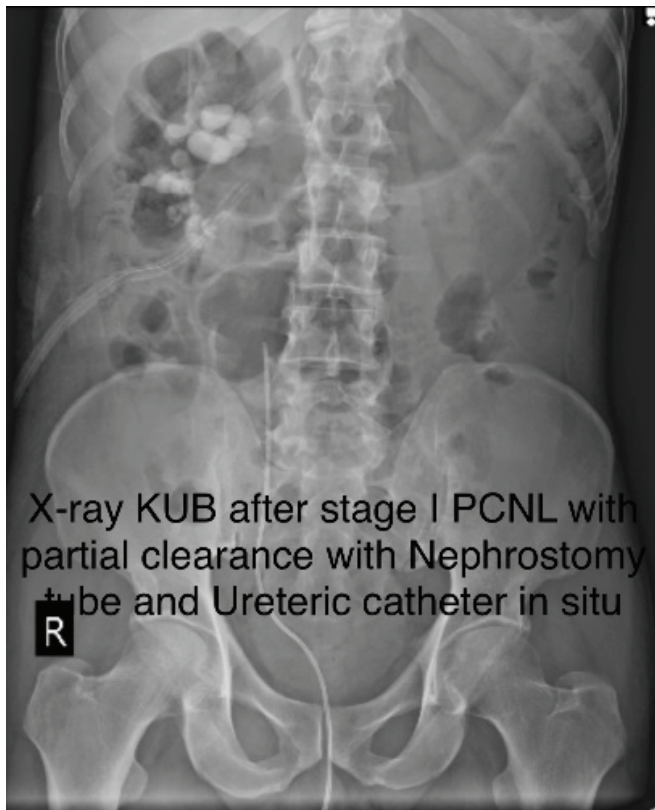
X-ray KUB after stage I PCNL with partial clearance with Nephrostomy tube and Ureteric catheter *in situ*
